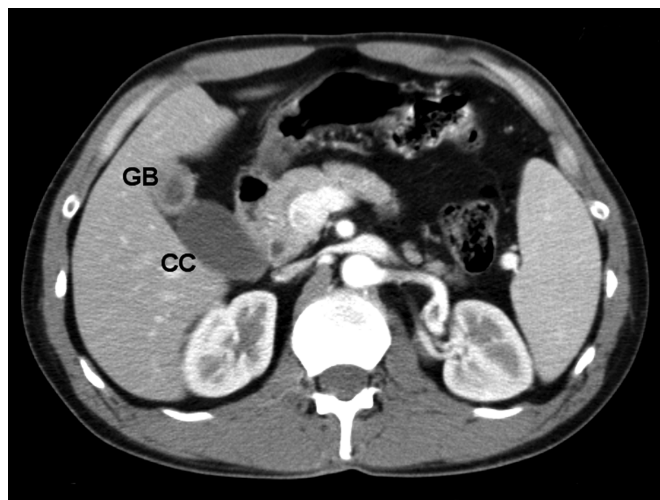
CT scan (GB=gallbladder, CC=choledochal cyst).
